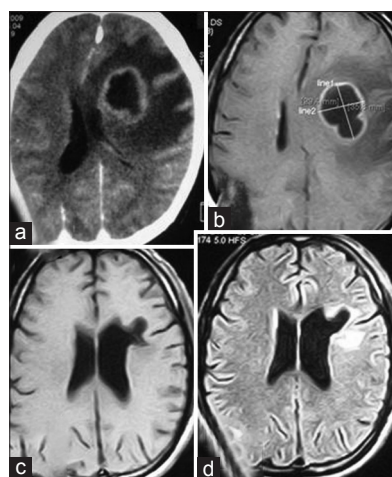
(a) Preoperative contrast CT axial section and (b) preoperative contrast MRI showing left sided paraventricular abscess with mass effect and edema; (c) posttreatment MRI of brain in T1W axial section and (d) posttreatment MRI axial section in fluid-attenuated inversion recovery showing complete resolution of abscess with some gliosis and cerebromalacia. CT: computed tomography; MRI: magnetic resonance imaging
